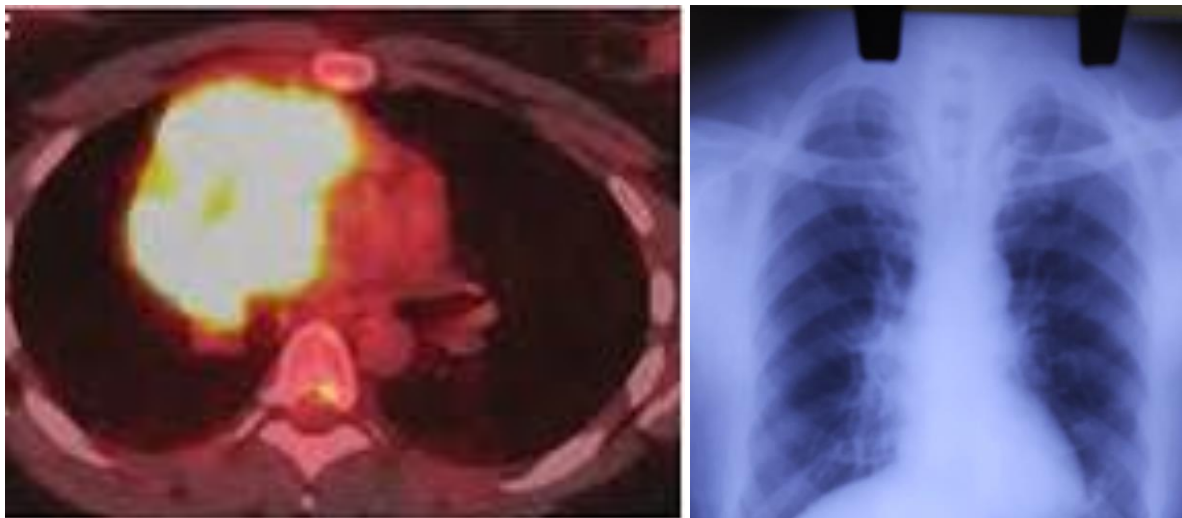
c) PET-CT shows the mass was intensely FDG avid, with a SUV_{max} of 15.5, d) Chest X-ray of the patient at the end of the course of anti-tubercular treatment showing complete resolution of the right hilar mass
